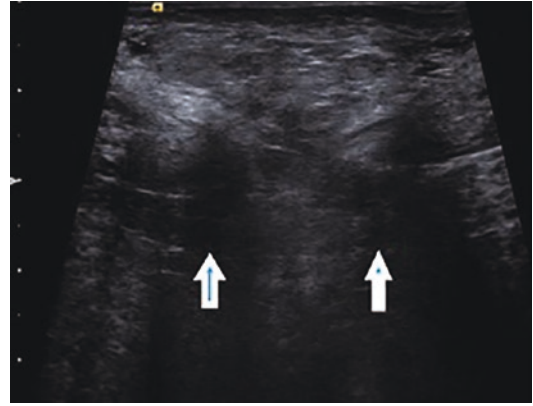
Ultrasound of umbilical defect. Arrows indicate the edges of the fascial defect
